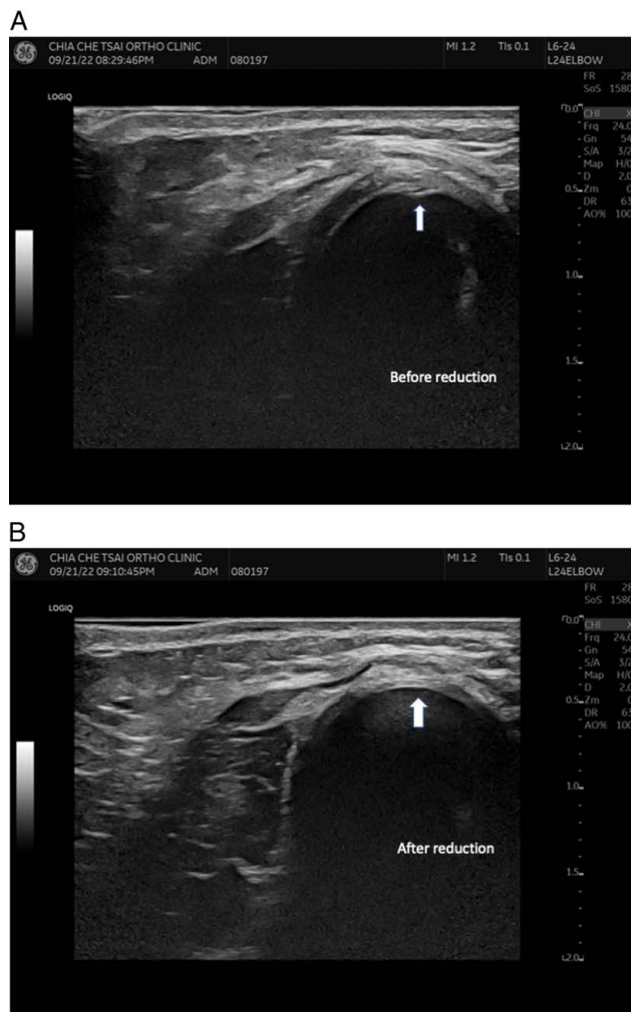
A, Sonographic image of the left side of a nursemaid’s elbow in a boy aged 2 years and 10 months. The posterior fringe (arrow) was entrapped between the radial head epiphysis and annular ligament. B, After reduction, the “partial eclipse sign” disappeared (arrow).
